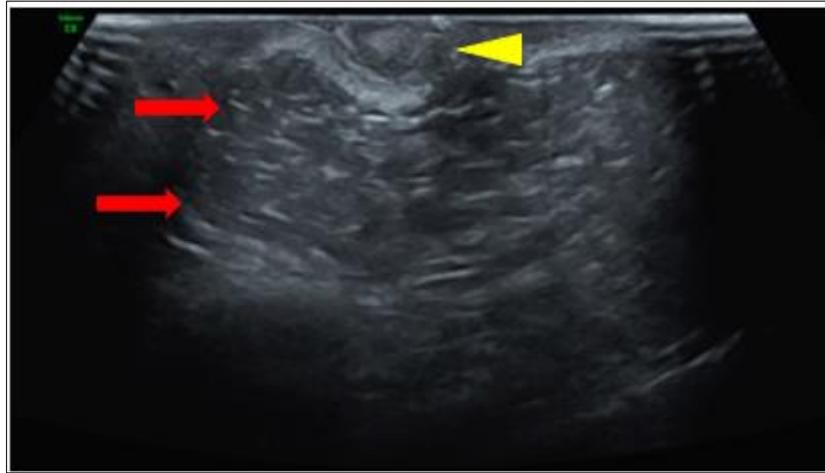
Scrotal ultrasonography showing a perineal lipoma (red arrow) associated with an accessory scrotum (yellow arrowhead)
